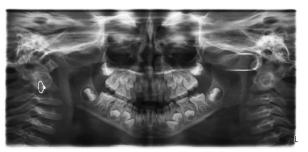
Post-operative panoramic radiograph showed normal alveolar mucosa and there was no damage to Permanent tooth bud
